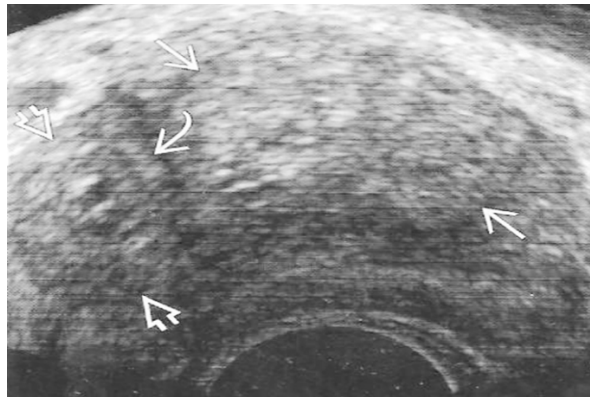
Shows a Trans rectal ultrasound image of chronic prostatitis. | Simon, PK Landis 1999.
